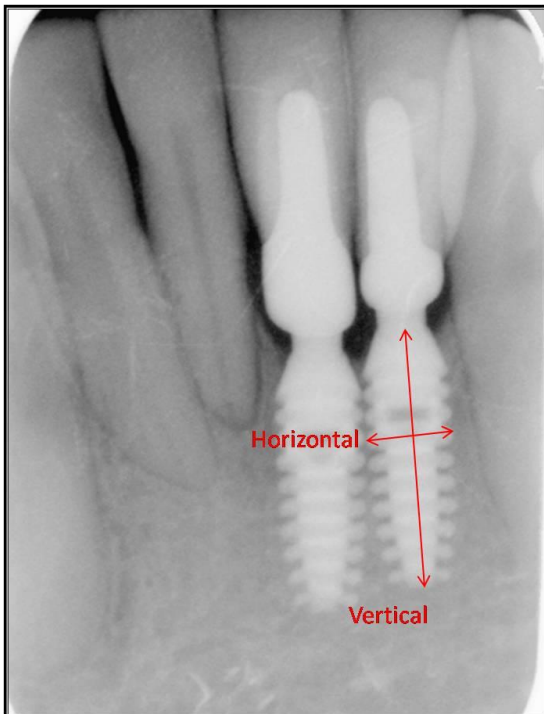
Vertical and horizontal radiographic implant measurements.
